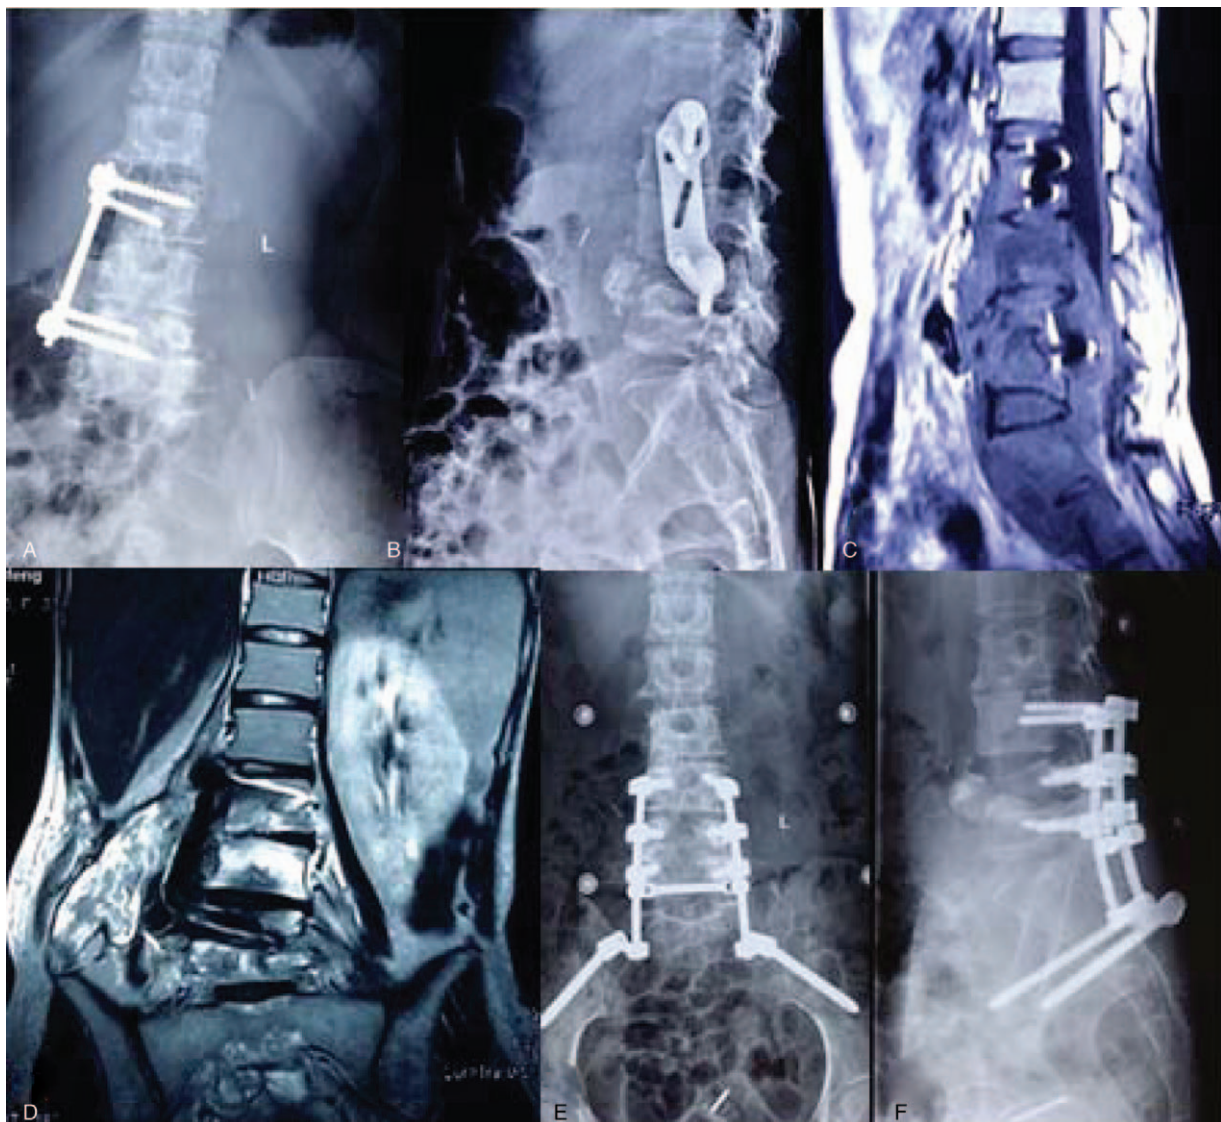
Case 2: A 63-year-old female with spinal tuberculosis recurrence after anterior approach. (A, B) radiographs showing screw dislocation. (C, D) MRI showed vertebral bone destruction and paravertebral abscess formation, serious spinal cord compression. (E, F) The patient underwent one-stage anterior debridement, interbody fusion, posterior instrumentation, and postural drainage. At final follow-up, fixation was in good shape, without signs of tuberculosis recurrence. CT=computed tomography, MRI=magnetic resonance imaging.
